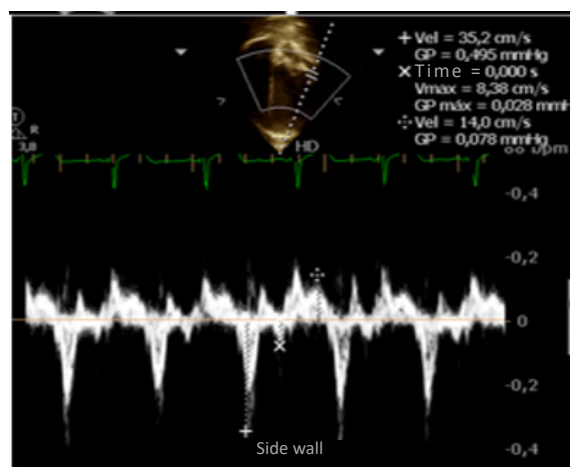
Position of the sample volume in TDI and tissue Doppler evaluation at color
